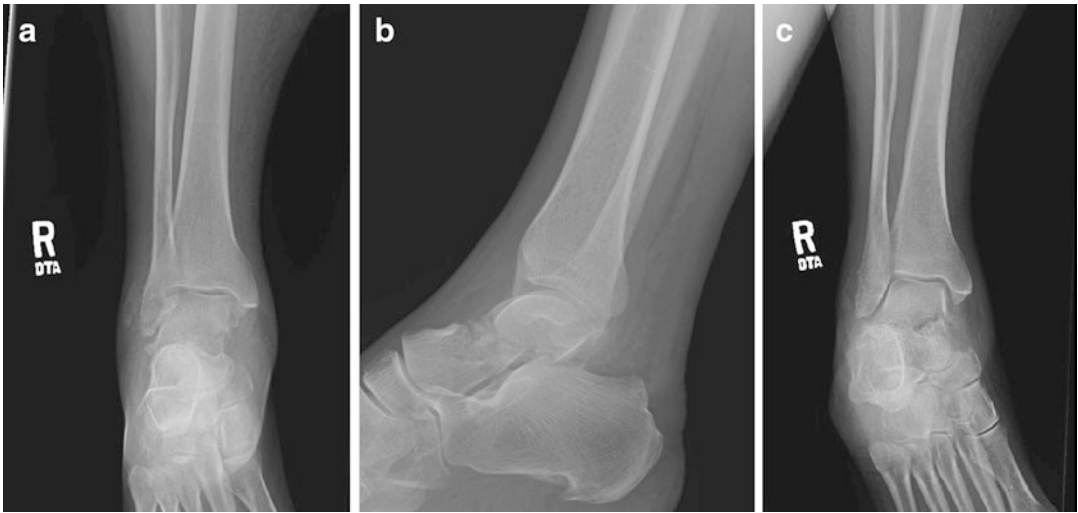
(a) AP radiograph ankle (b) Lateral radiograph ankle (c) Mortise radiograph ankle
